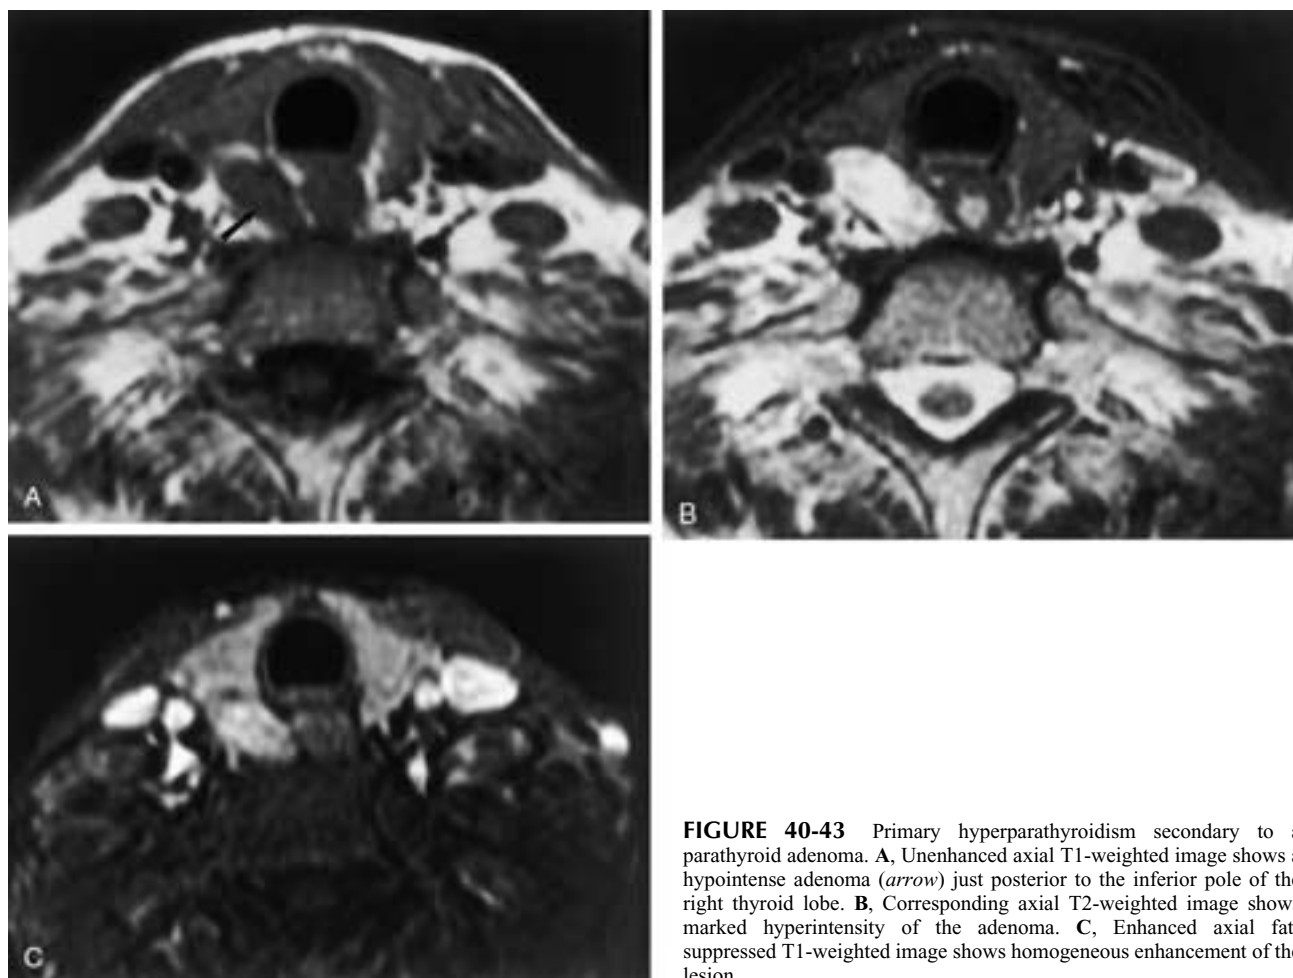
Primary hyperparathyroidism secondary to a parathyroid adenoma. A, Unenhanced axial T1-weighted image shows a hypointense adenoma (*arrow*) just posterior to the inferior pole of the right thyroid lobe. B, Corresponding axial T2-weighted image shows marked hyperintensity of the adenoma. C, Enhanced axial fat-suppressed T1-weighted image shows homogeneous enhancement of the lesion.
